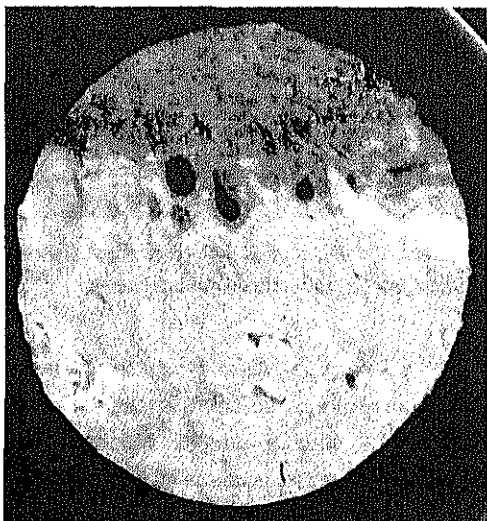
Phase-contrast x-ray CT image of gallbladder cancer. Diameter of sample is 10mm.
